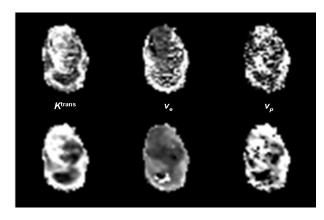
An example of comparison between CT (top) and MR (bottom) parametric maps.
